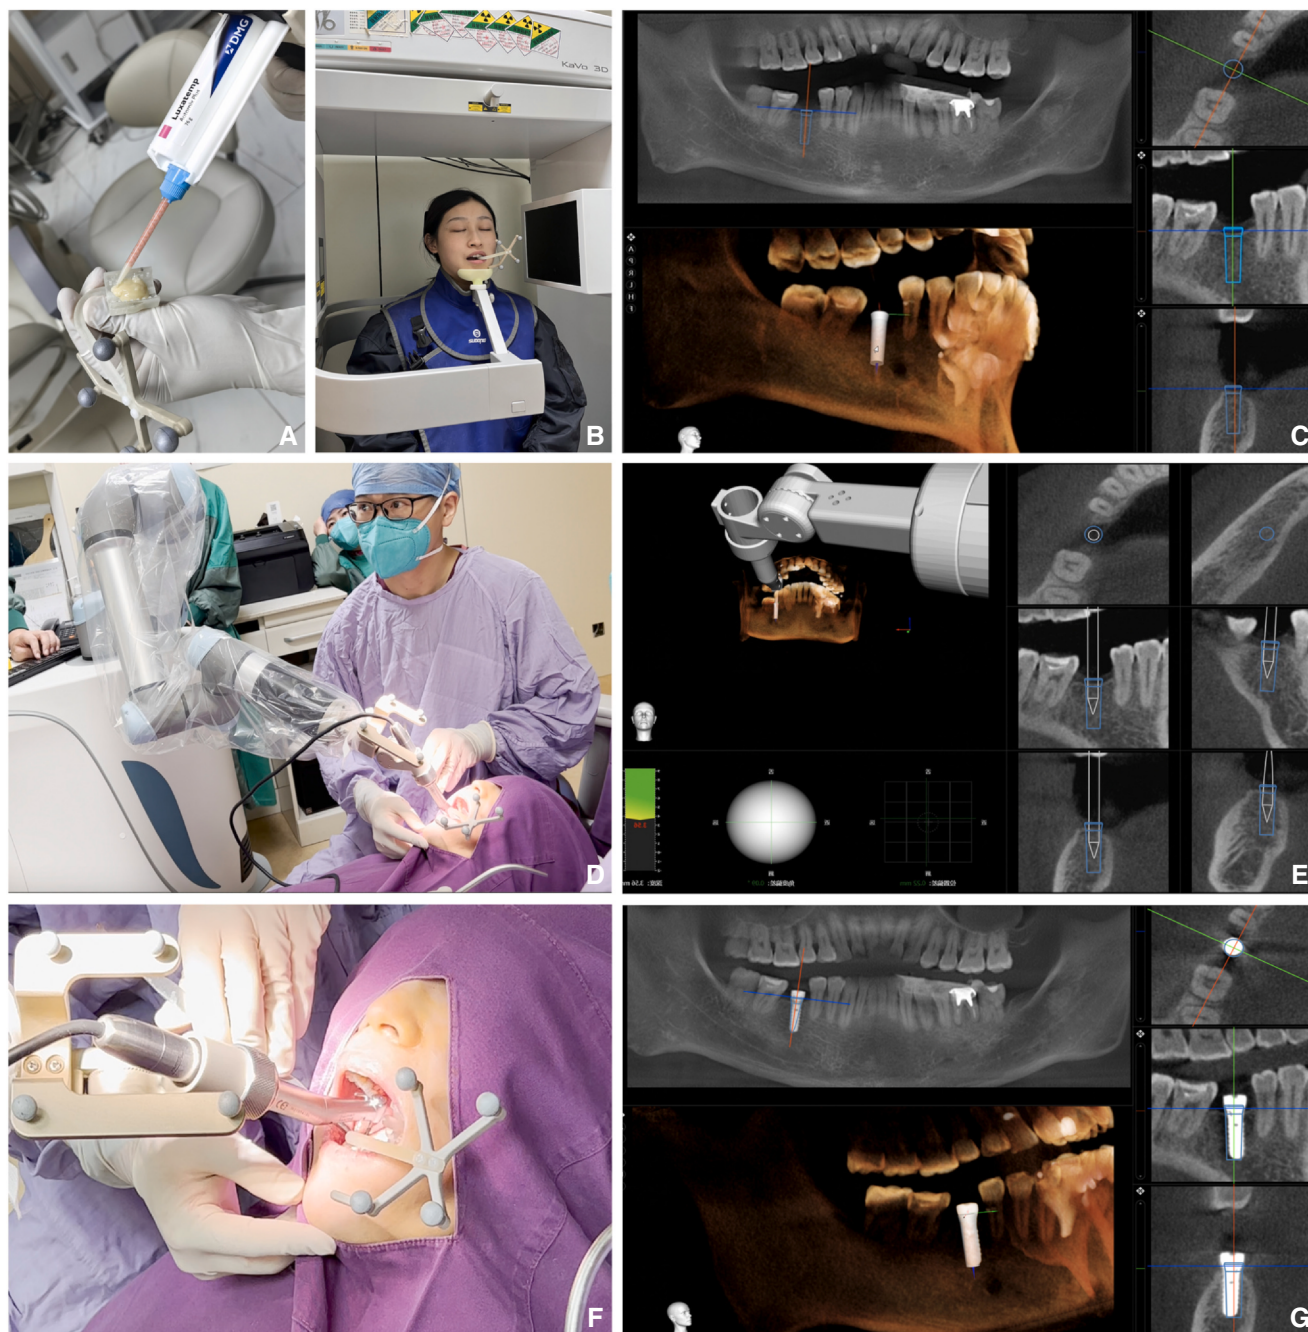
Surgical process of autonomous dental implant robotic system. A, Positioning marker fixed to contralateral tooth of same jaw at patient's implant site using interim crown material. B, Preoperative CBCT examination of participant with positioning maker. C, Treatment plan designed before surgery. D-F, Autonomous dental implant robotic system in use. G, Postoperative evaluation: comparing accuracy of preoperatively planned implant position (in blue) with actual postoperative position.
